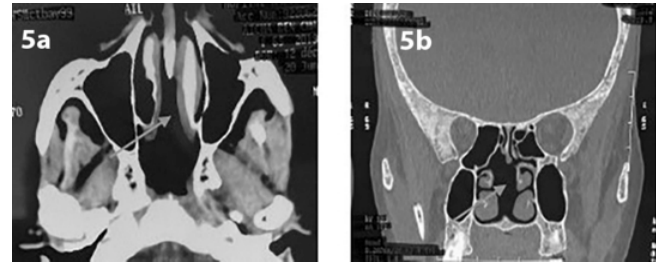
Facial mass CT scan in axial (a) and coronal (b) sections: showing a nasal fossa free of tumor, the nasal septum was removed (arrow)
